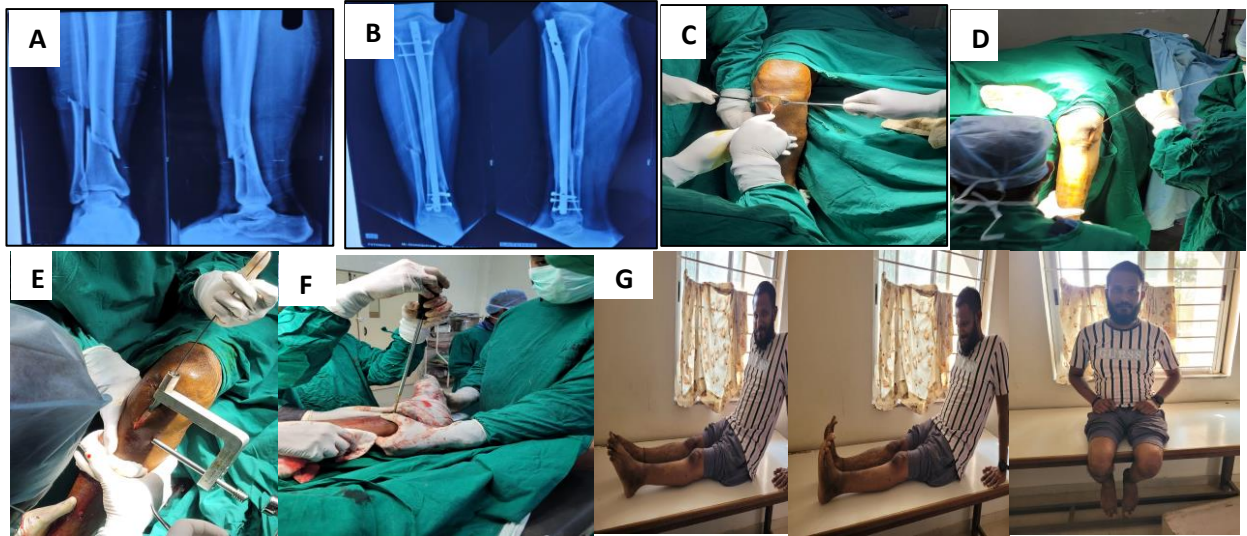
Closed reduction and internal fixation with intramedullary nailing. (A) Pre op X-ray; (B) post op X-ray; (C) skin incision; (D) insertion of guide wire; (E) insertion of intramedullary nail; (F) distal bolt locking; (G) patient showing full rom at 6 months follow up after intramedullary nailing
